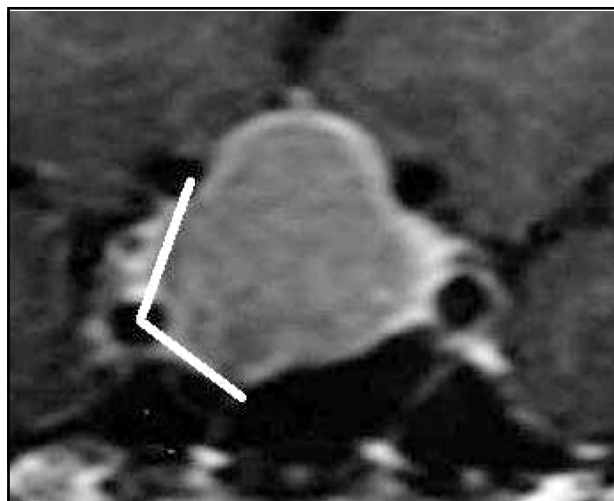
Coronal T1 MR image after contrast enhancement showing the technique for measurement of the percentage of encasement of the ICA by PA (right CS invasion).
